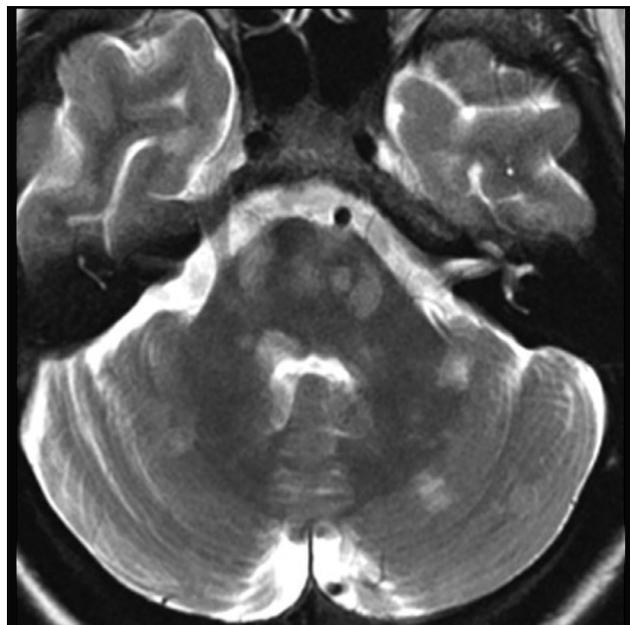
Axial T2-weighted sequence. Multifocal WMH in brainstem, middle cerebellar peduncles and cerebellar hemispheres, in a patient with MS
